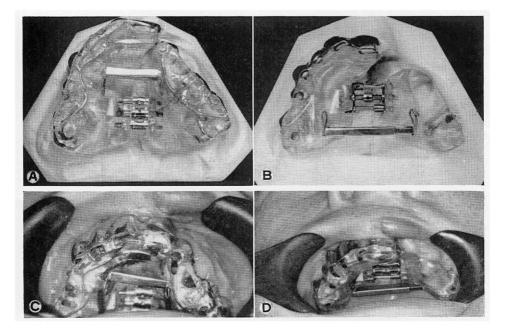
Case I: unilateral cleft. (a) Splint on model before expansion. (b) Splint on model after expansion. (c) Splint in situ before expansion. (d) Splint in situ after expansion. (e) X-ray films showing splint before and after expansion. (f) X-ray films before expansion and after expansion and insertion of bone graft. (g) Articulated models before and after expansion. (h) Bite before expansion. (i) Bite after expansion and insertion of bone graft. (j) Gap created filled with two teeth on denture.
